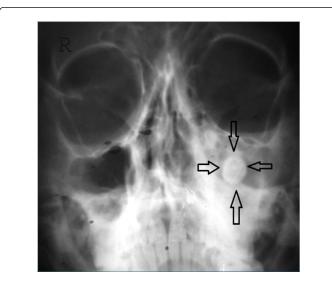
PA radiograph of PNS region shows an ovoid focal radiodensity (arrows) in left maxillary region with partial opacification of left maxillary sinus.
